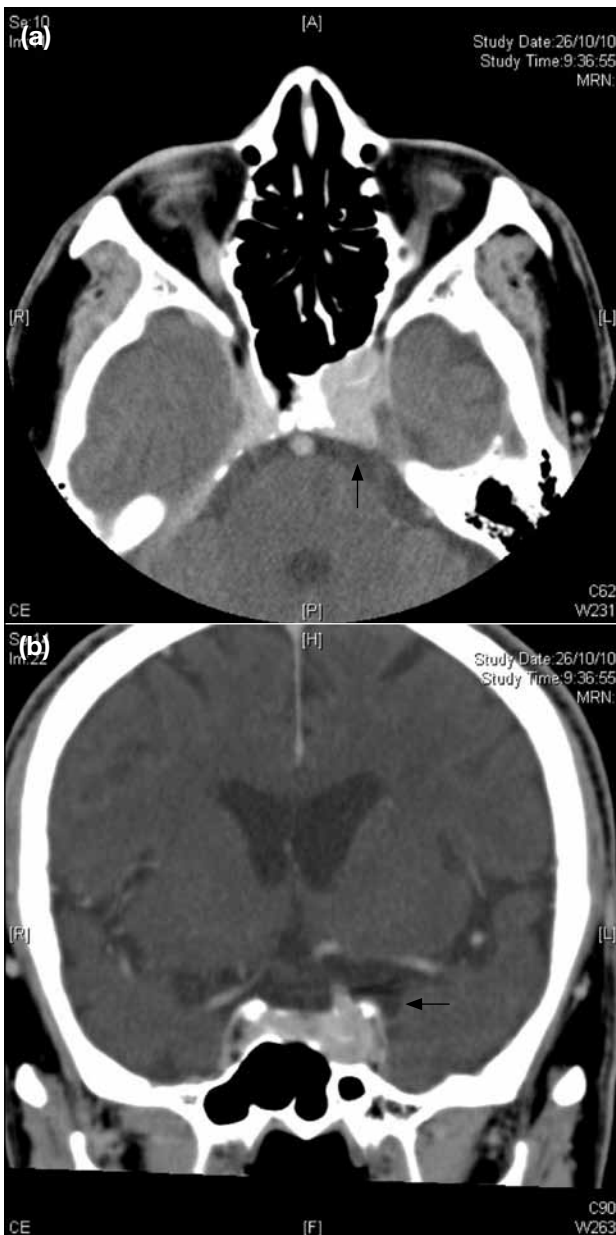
Contrast-enhanced computed tomography scans showing (a) an enhancing soft tissue lesion (arrow) at the left cavernous sinus with bony erosion, and (b) coronal view showing the left distal internal carotid artery exiting the lesion (arrow).
